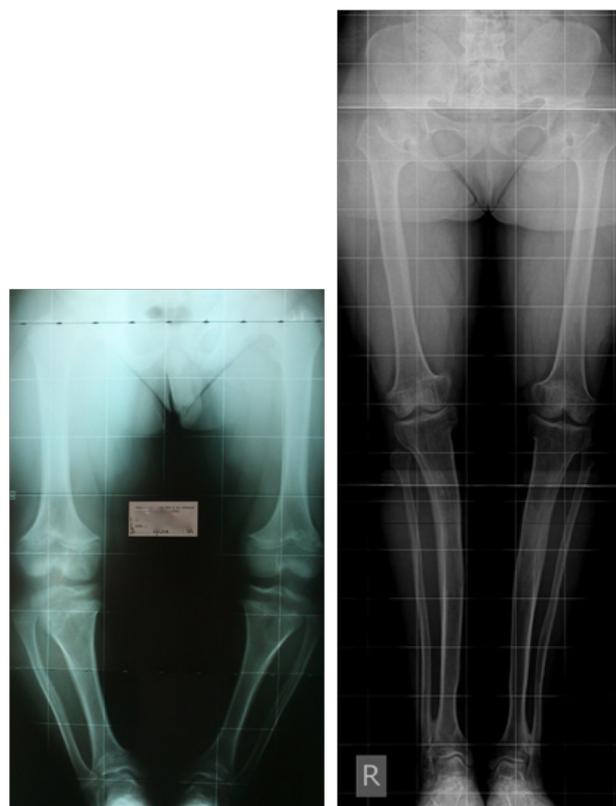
a. Pre- operation and b. post-operation X-rays of achondroplastic patient undergone lower limb lengthening with the Ilizarov frame.
